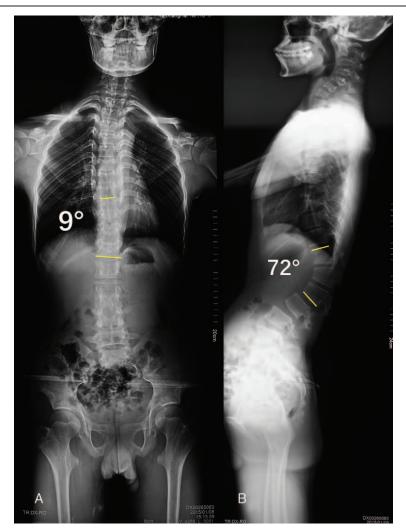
Upright radiographs of the whole spine of the 16-year-old proband, (A) anteroposterior radiograph showing a Cobb angle of 9° at T9 to T12. (B) sagittal radiograph showing obvious kyphosis and a Cobb angle of 73° at L1 to L3.
